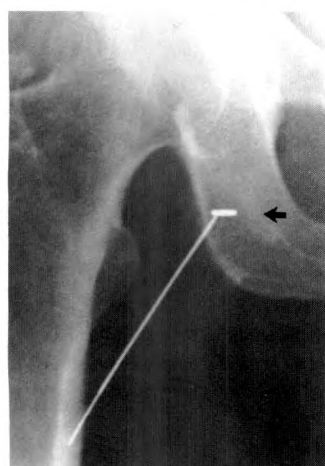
Radiograph shows lead marker (arrow) taped to skin, marking entry site of the needle into artery.
